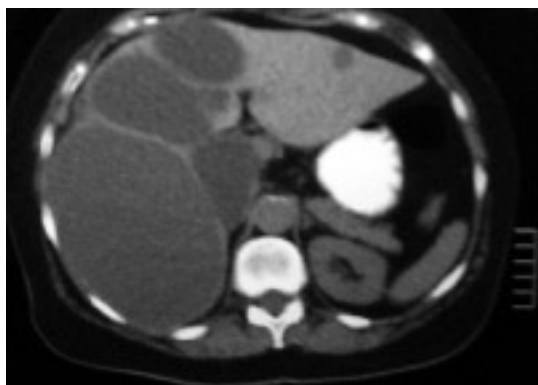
CT scan demonstrating multiple unilocular liver cysts. The cysts are well delineated, smooth with uniform content, consistent with simple liver cysts.
